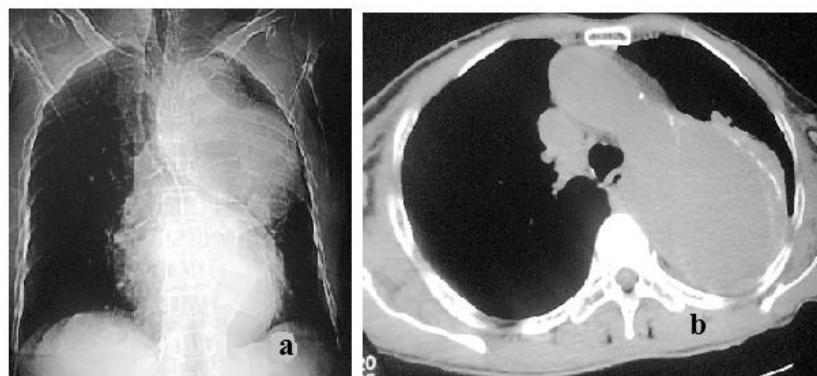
CT scan images of a large aneurysm of the descending aorta with an oblique intimal flap.
